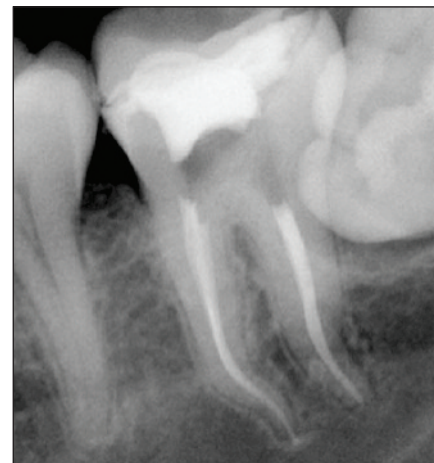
Post-op radiograph of a mandibular molar case with .04 tapers and BC Sealer. Notice the endodontic synchronicity of the preparation and obturation particularly in the mesial canals. Courtesy of Dr. Alex Fleury, Dallas.
